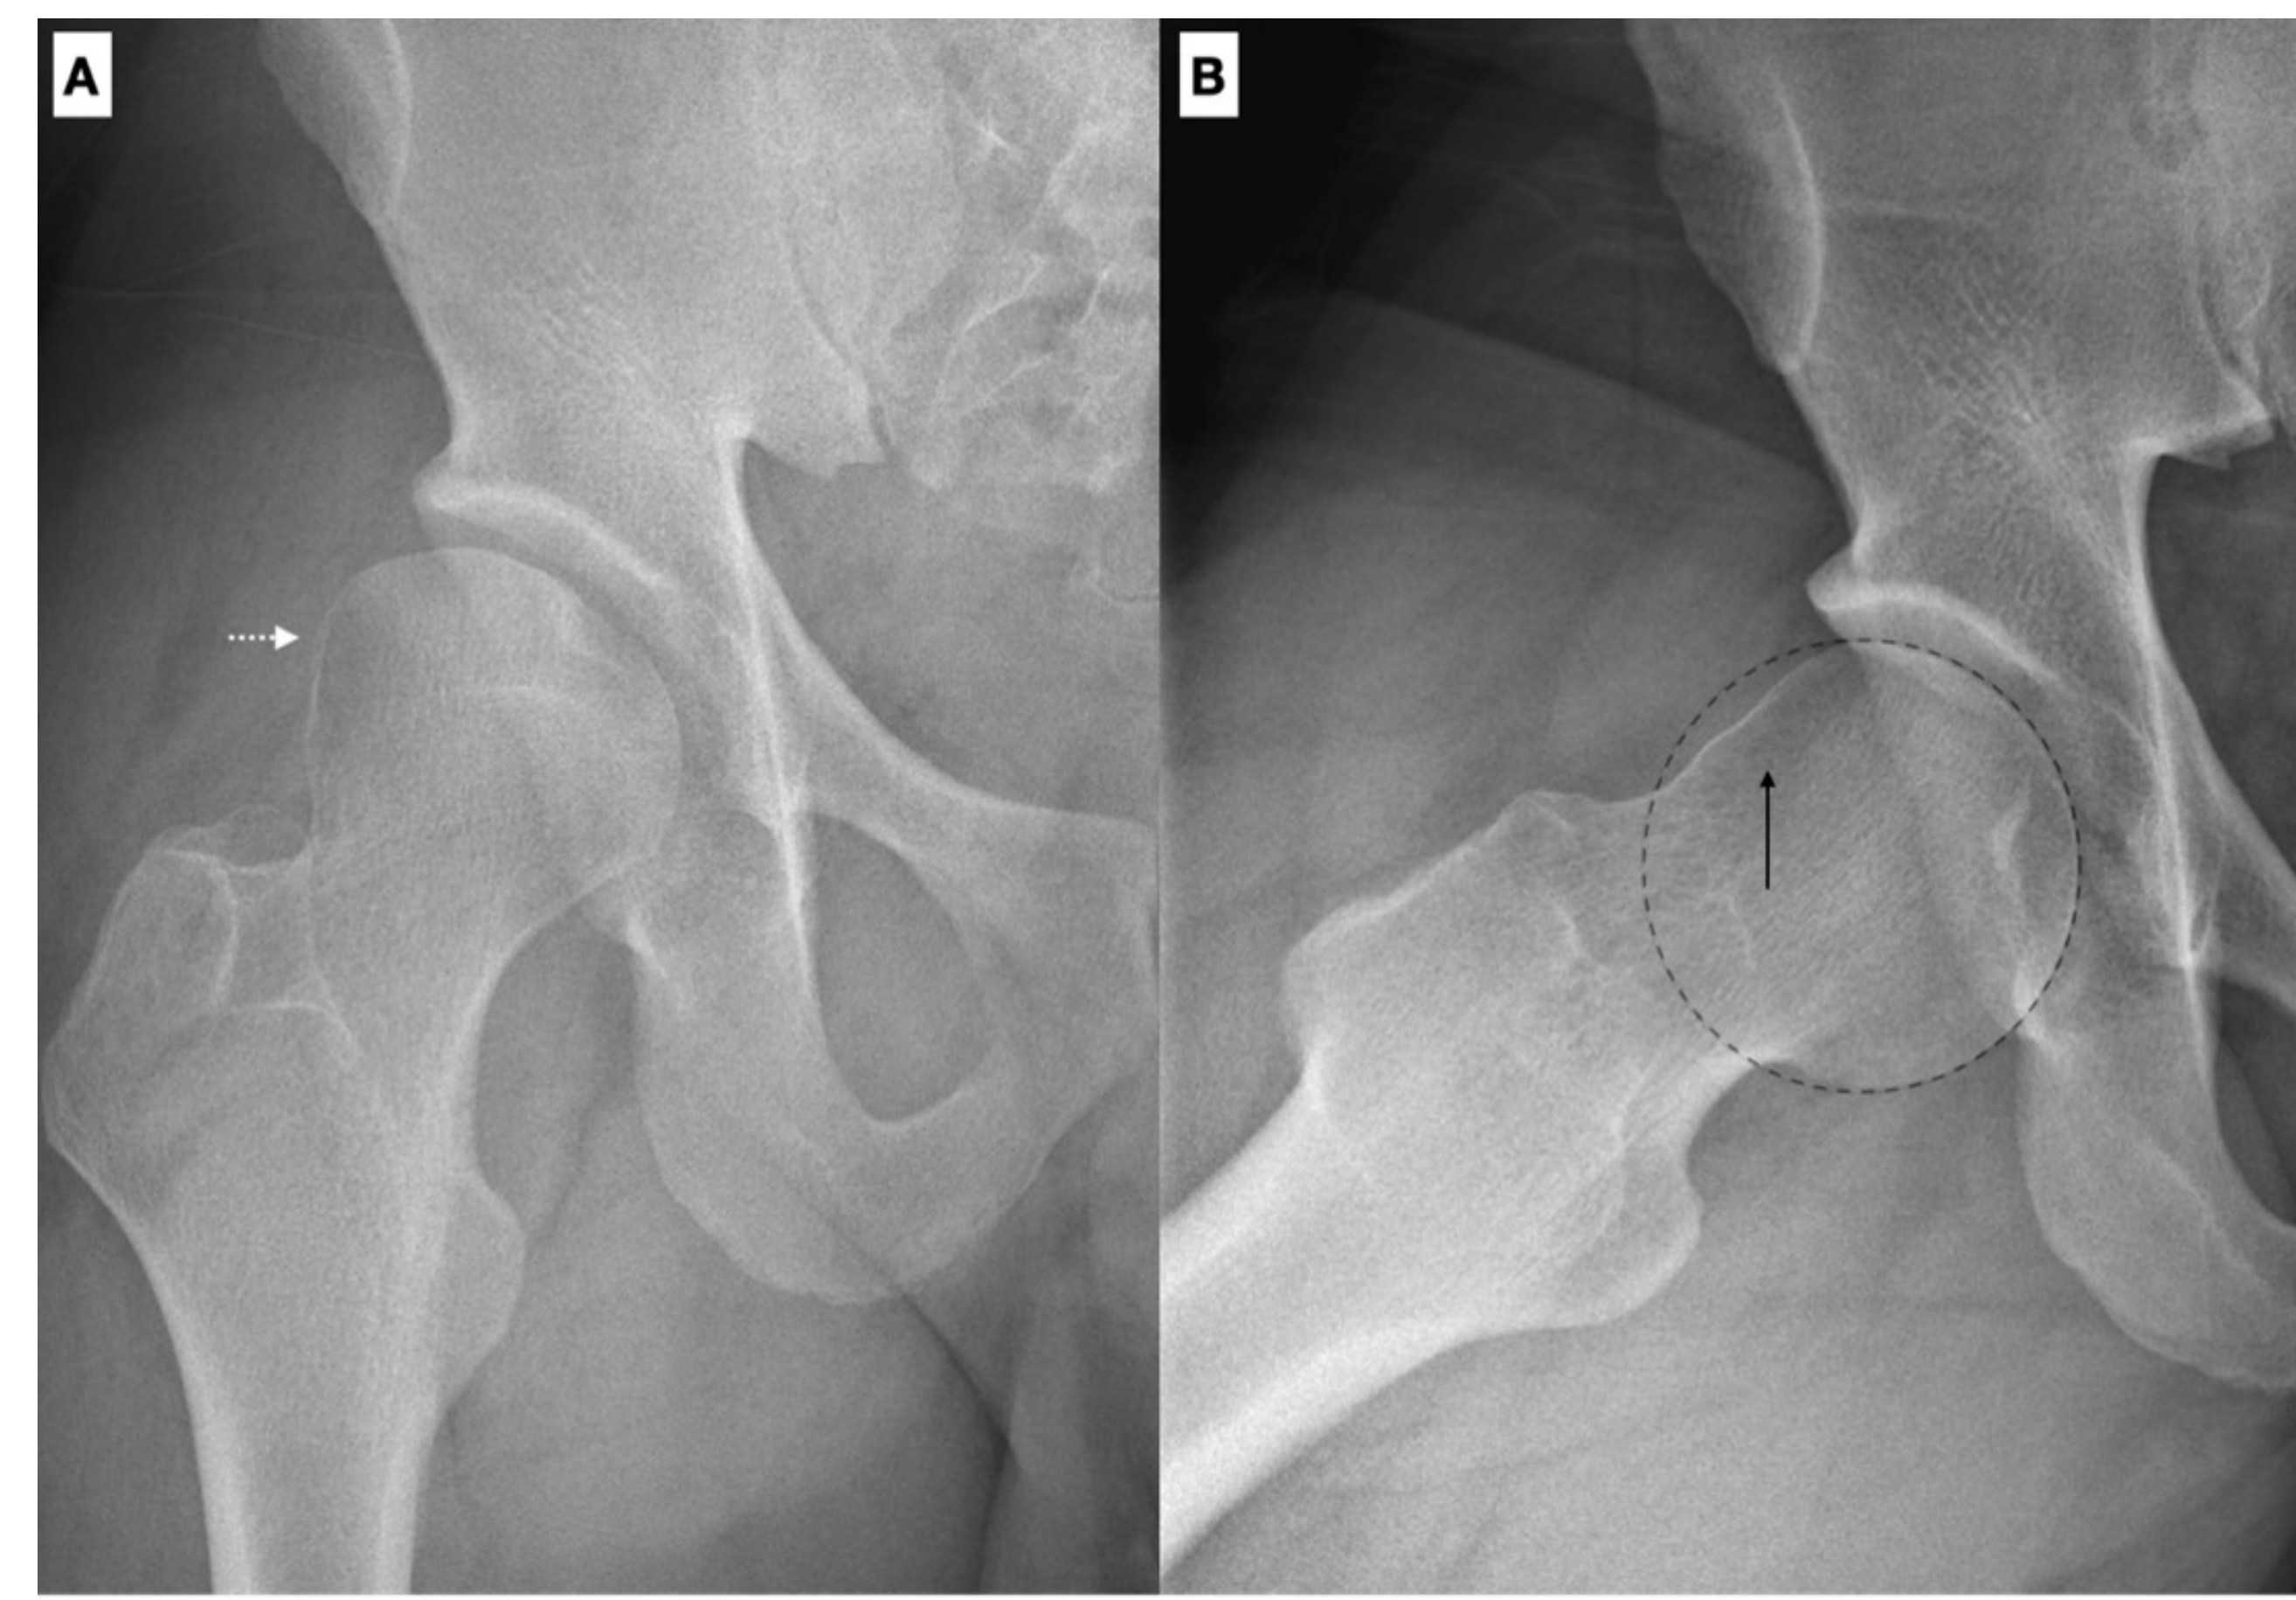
Preoperative anteroposterior (AP) and frog leg lateral radiographs demonstrating a WSW sign of the right hip in a patient with no prior surgical history. A) AP radiograph with a white arrow pointing toward a flattened area over the anterolateral femoral head. B) Frog leg lateral radiograph demonstrating a localized linear flattening of the anterolateral femoral head-neck junction resulting in a focal divergence from the normal femoral head sphericity (black arrow).
